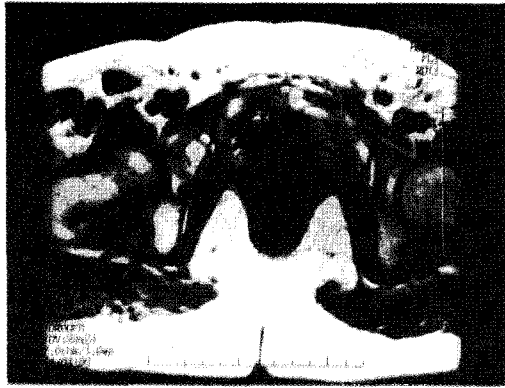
2001. 5. 28. MRI in pevis
